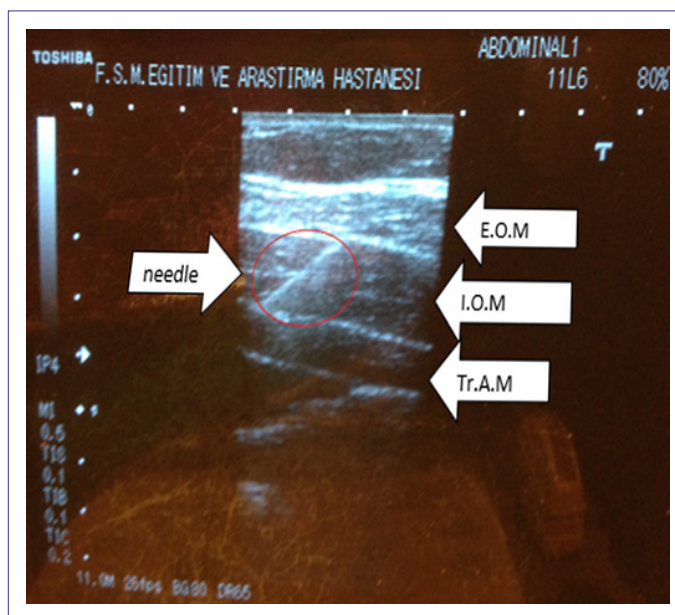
Ultrasound image during initial injection, image of the needle and the muscle layers.
